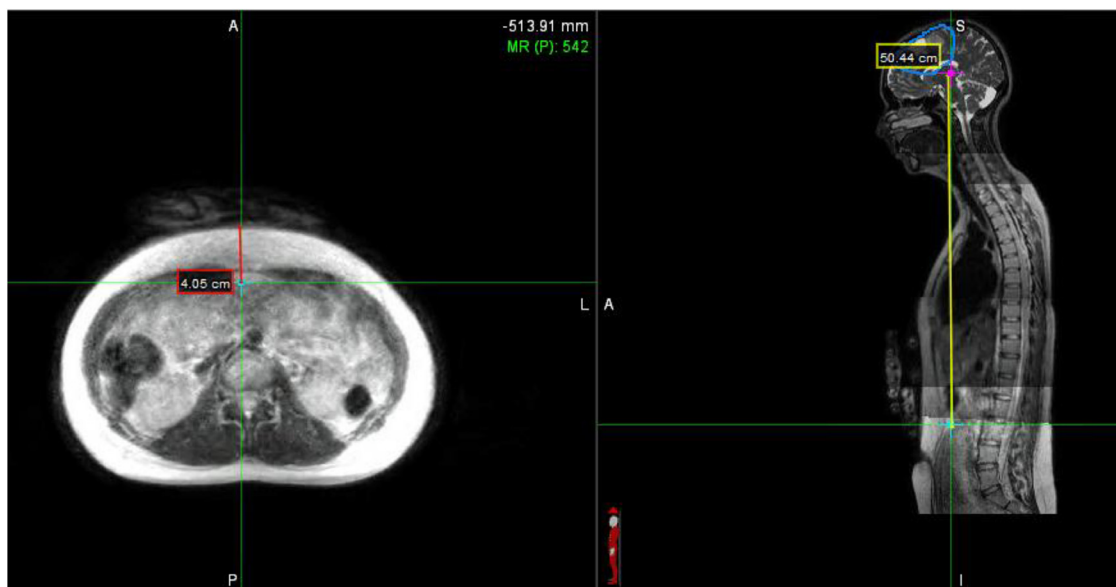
Stacked MR with MR-Sim Separation + Depth. Sagittal and transverse MR images from the stitched 768-slice data set. This allowed for precise measurement of the separation (51.4 cm) between the inferior extent of the target and the uterine fundus, as well as the fundus depth (4.0 cm).
